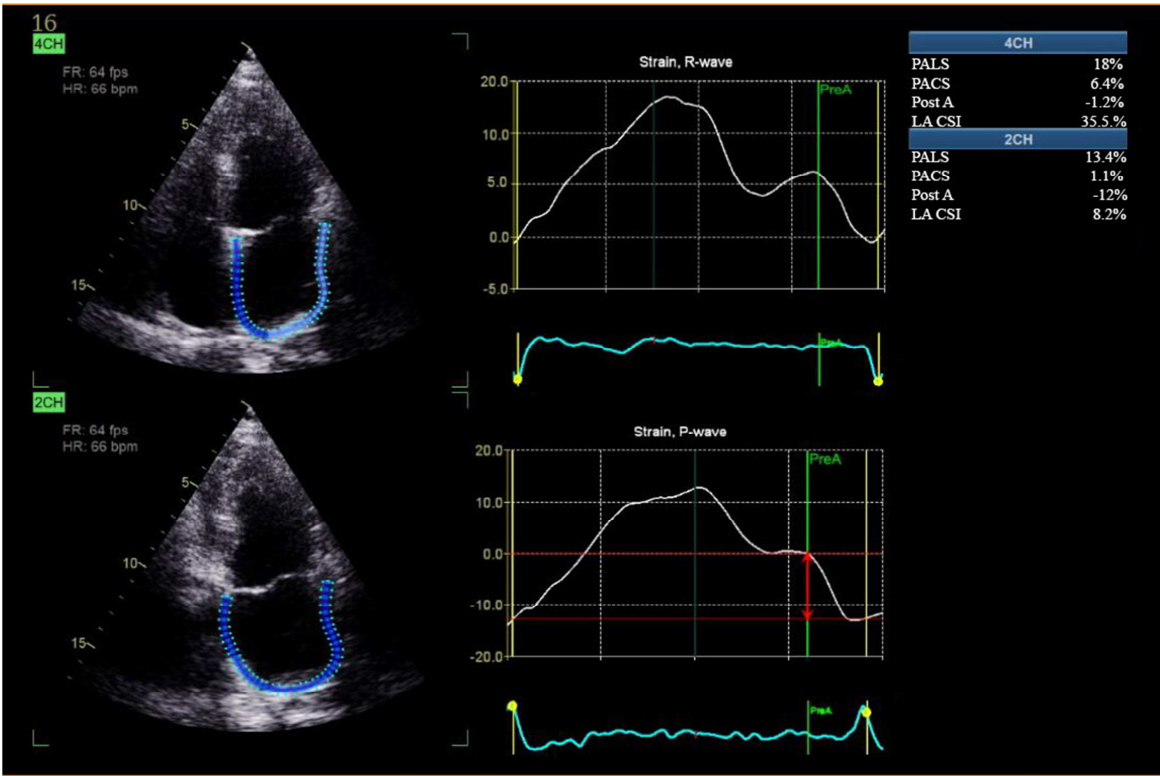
Apical 4 chamber view, Apical 2 chamber view shows strain curve and strain numeric values walls of LA in a diabetic patient with CAD. A cardiac cycle is tracked, the septal, lateral, inferior wall of LA is divided into 3 segments (basal, mid and apical) that are color coded, and strain curve is obtained. (PALS) in 4CH and 2CH views are 18% and 13.4% respectively, and PACS in 4CH and 2CH views are 6.4% and 1.1% respectively. The post-A which is the peak negative value after atrial contraction is -1.2 and -12% in 4CH and 2CH respectively.
